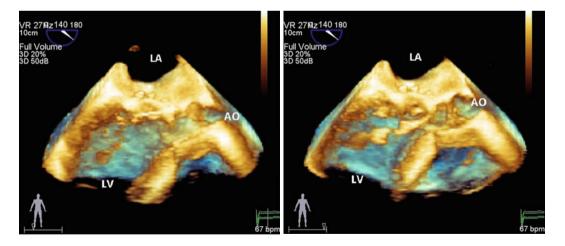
3D TEE color Doppler, showed severe eccentric MR (*arrow*)
